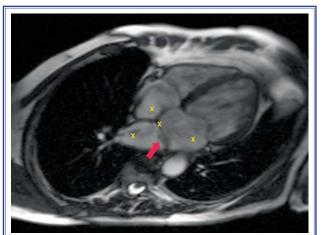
In cardiac magnetic resonance imaging, two fibromuscular membranes are clearly seen dividing the left atrium into three chambers.
